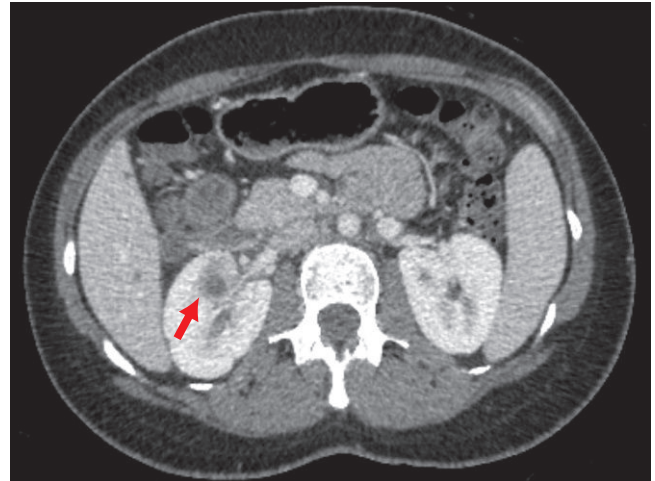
Contrast-enhanced CT demonstrating an area of decreased density noted within the right kidney (arrow).
